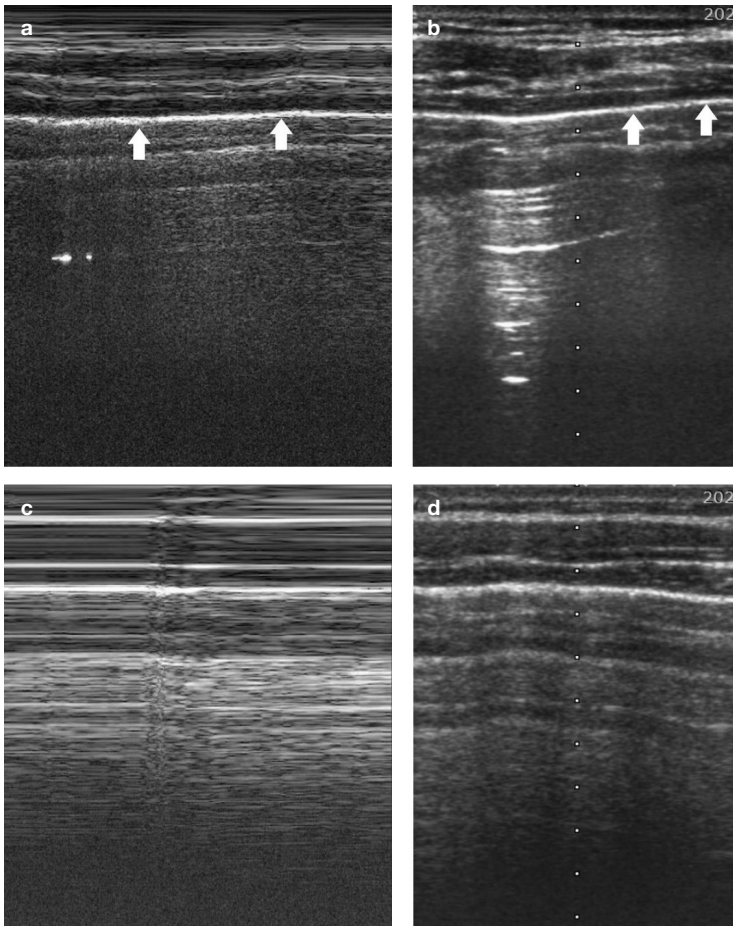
The presence of an image resembling sea waves caused by pleural sliding in “a” indicates the absence of pneumothorax. The arrows in “a” and “b” indicate the pleural line. “c” and “d” are images of the thorax US of a patient with pneumothorax. In “c” it is seen that the “seaside” finding has disappeared. This view in the M mode of ultrasound is also called the “barcode/stratosphere” sign which is highly sensitive for the diagnosis of pneumothorax.
